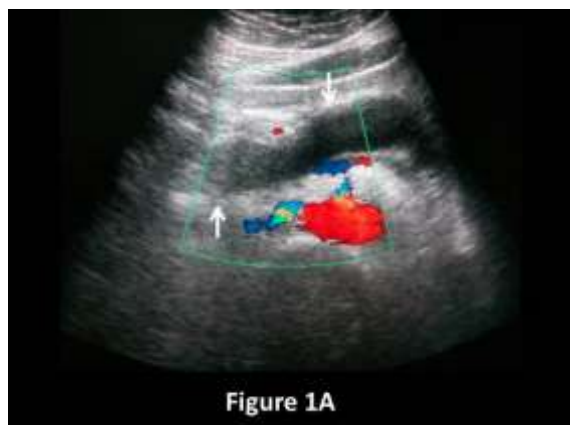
Colour Doppler ultrasonography of abdomen, showing dilated main pancreatic duct i.e. duct of Santorini (white arrow) showing no colour uptake.
